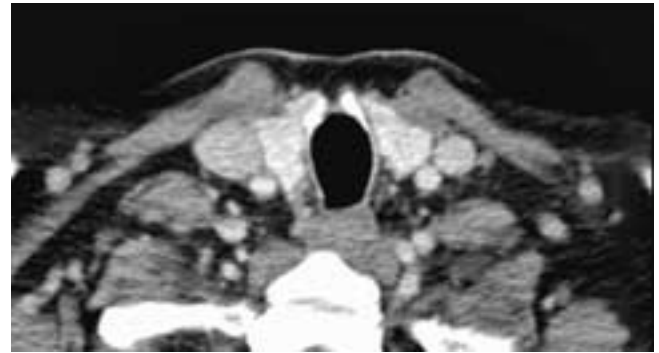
Axial contrast-enhanced CT scan shows separation of the anterior tracheal cartilage at the site of a prior tracheostomy.
